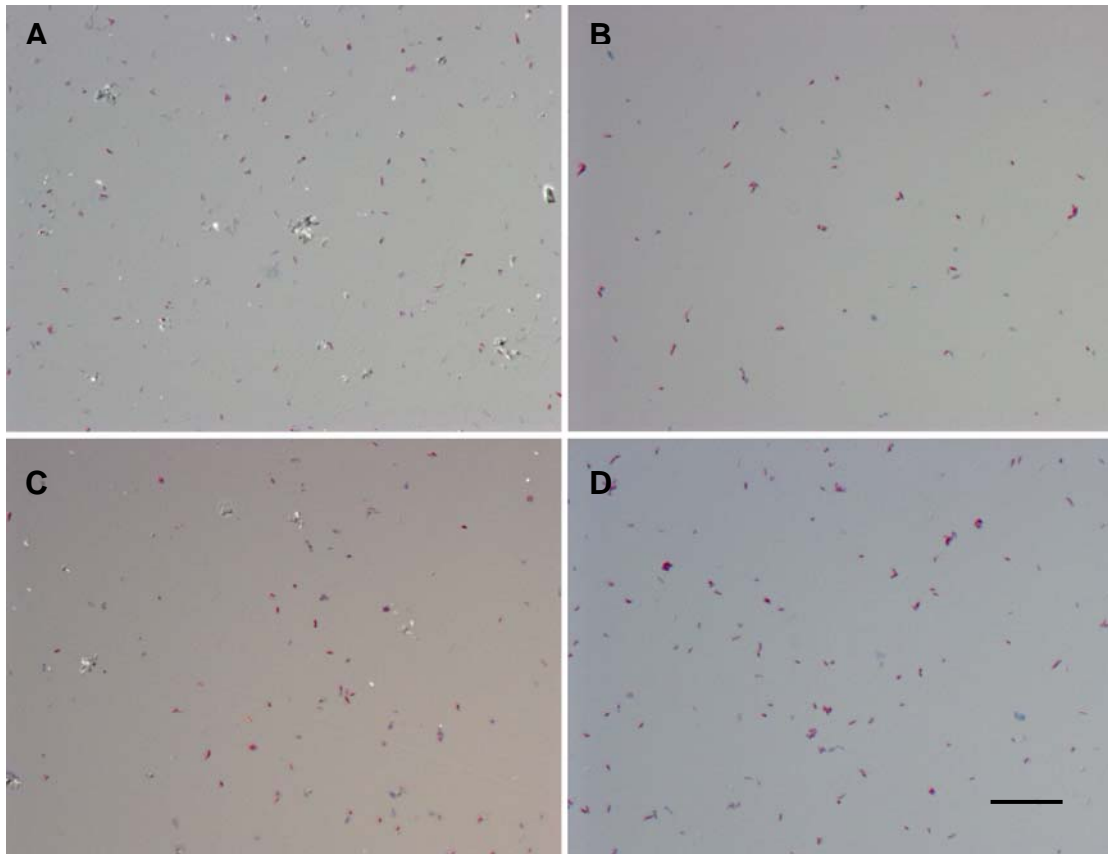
Map bacteria after sonication. Images show Map before (A) and after sonication for 10 (B), 20 (C), and 30 (D) seconds. The sonicator was set to 10% power with a 50% pulse (Omniruptor 4000 ultrasonic homogeniser). Scale bar indicates 10 $\mu$ m.
